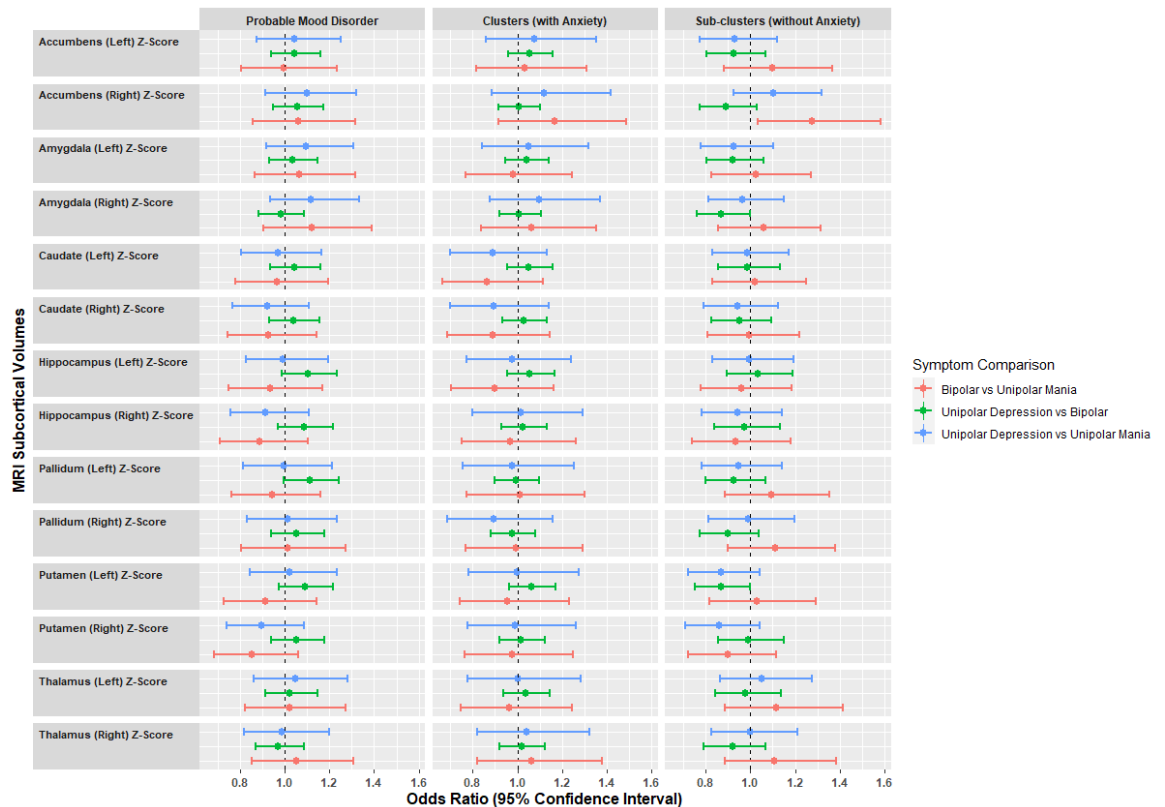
Odds ratios and their 95% confidence intervals for Magnetic Resonance Imaging (MRI) subcortical volumes.
